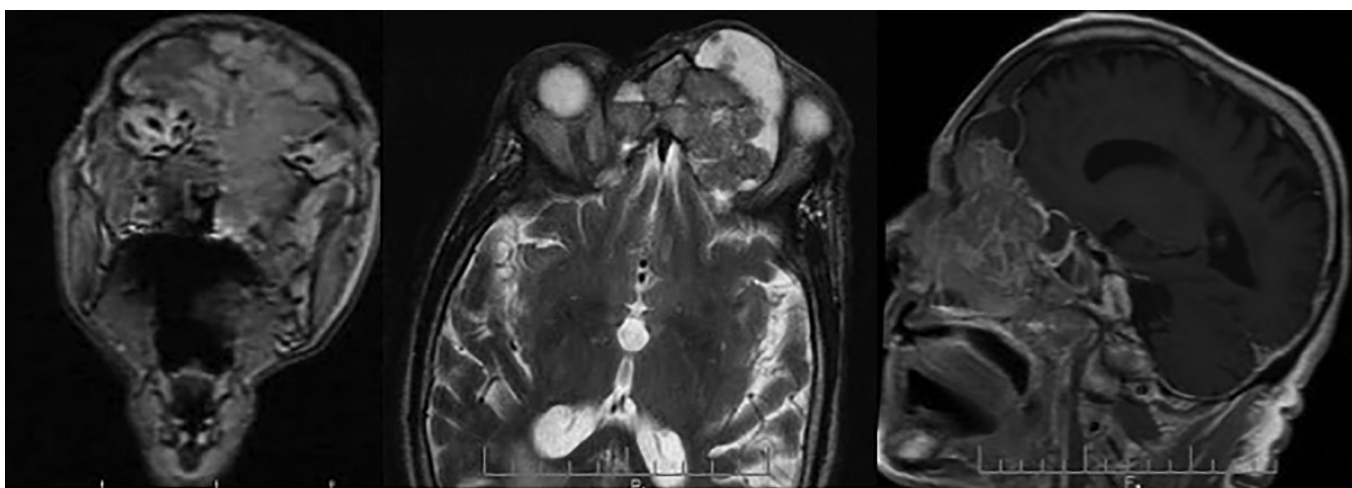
Pretreatment magnetic resonance imaging of the sinuses once again demonstrates the extensive left-sided disease with associated mucocele.
